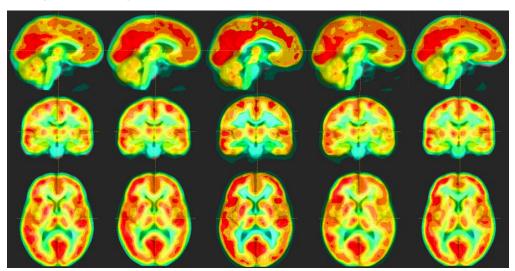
Registration results of overlaying registered PET from a patient to the atlas by using 5 registration methods. From left to right, (1) NMI/DCT (SPM2), (2) NMI/linear (Hermes) (3)RIU/Affine (AIR), (4)CC/linear (MIPAV), and (5) NMI/FFD (CISG). The colors from blue to green, yellow, and red represent increasing FDG uptake of PET images. AIR provided best accuracy by aligning low FDG uptake on PET with CSF/WM on the MR atlas.
